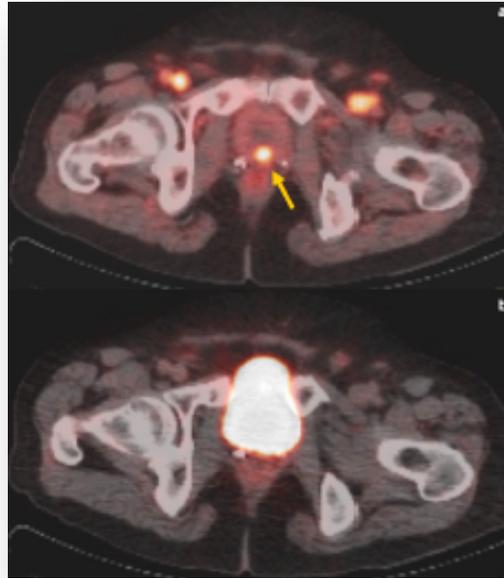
(a) Fused axial images of early imaging and (b) standard imaging of ^{68}Ga -PSMA PET/CT scan at the pelvic region. A focal PSMA avid lesion was seen at the prostate gland (yellow arrow) during early imaging which was not visible during standard imaging due to radiotracer activity within the urinary bladder. (Images sourced from Barakat *et al.*, 2020)
